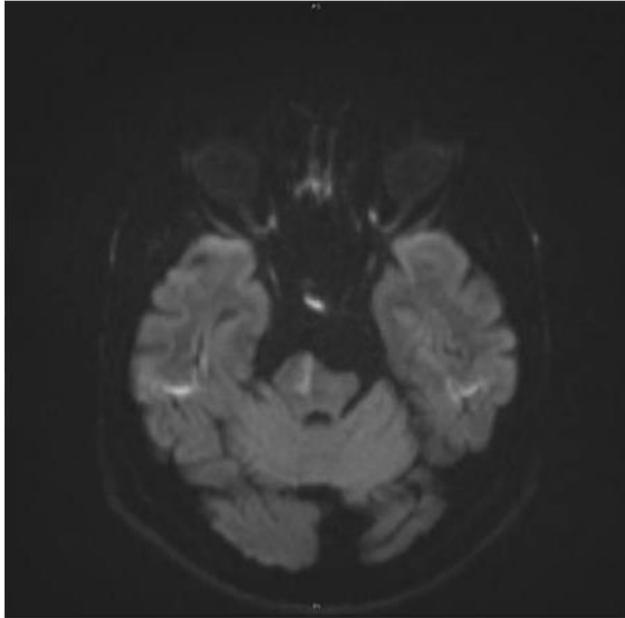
Cranial MRI (DWI-ADC).
